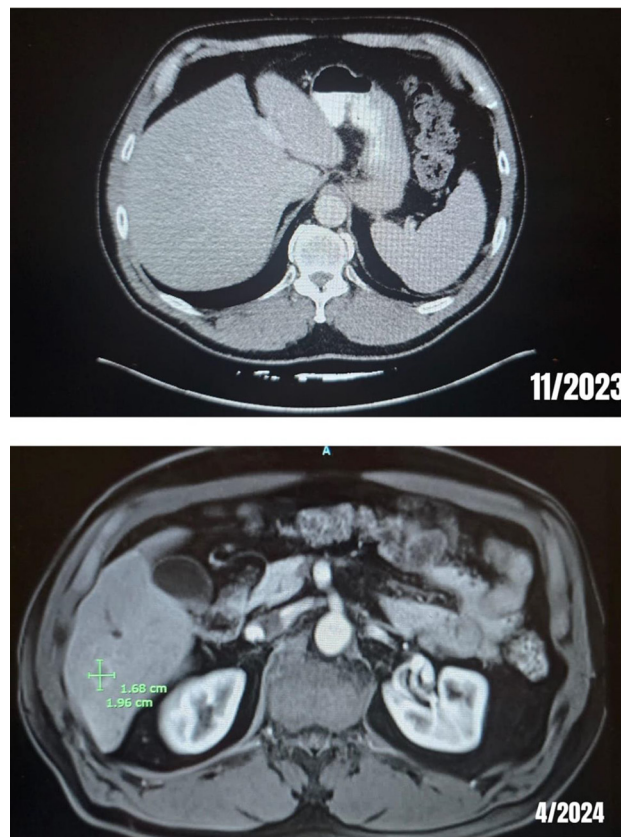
Computed tomography (CT) images of the liver in Case 2. (A) Surveillance imaging after surgery and adjuvant chemotherapy shows no focal hepatic lesion. (B) Follow-up CT obtained after ctDNA positivity demonstrates a solitary segment VII liver metastasis (arrow), which was subsequently confirmed and resected.
